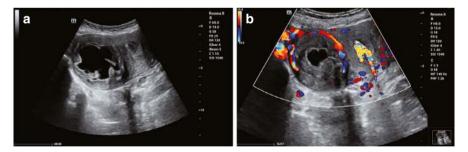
(a) A fibroid with cystic degeneration, characterized by an irregular fluid area within the fibroid. (b) A fibroid with cystic degeneration, showing semicircular blood flow around the fibroid on color Doppler ultrasound
